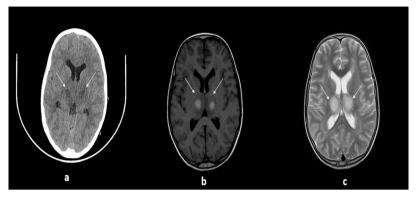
Axial CT (a) and T1W MRI (b), T2W MRI (c) images of the brain demonstrating bilateral symmetric hypodensities with areas of hemorrhage (white arrows in image a) and hyperintense signals on T1W, T2W MRI (white arrows in images b,c) suggestive of hemorrhages and surrounding edema in the bilateral thalami.
